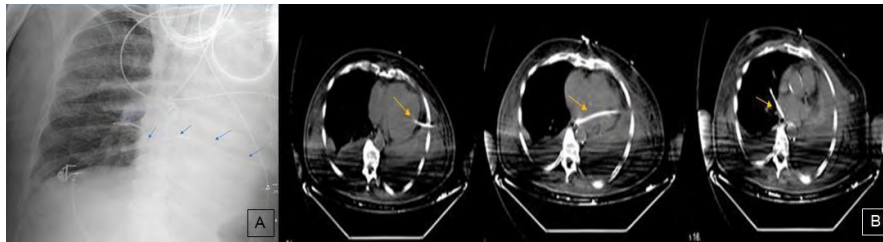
(A) Posteroanterior chest radiography shows pleural catheter malposition to contralateral hemithorax, marked with arrows. (B) Computed tomography shows tractus of pleural catheter through the whole mediastinum to the contralateral hemithorax, marked with arrows.
